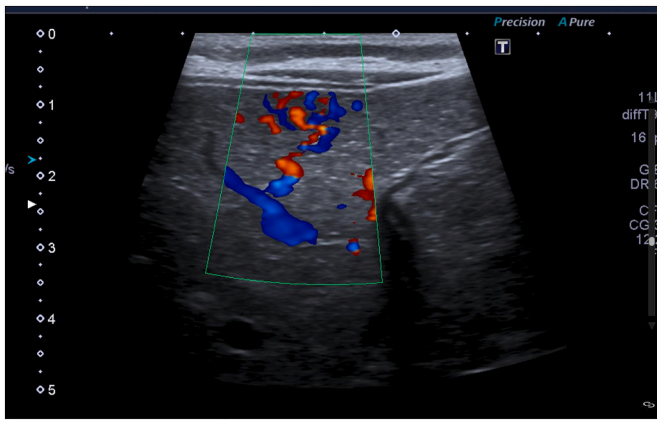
Doppler effect is used in a scan of the liver to assess the flows (portal, arterial) to differentiate the bile ducts and the vessels.
